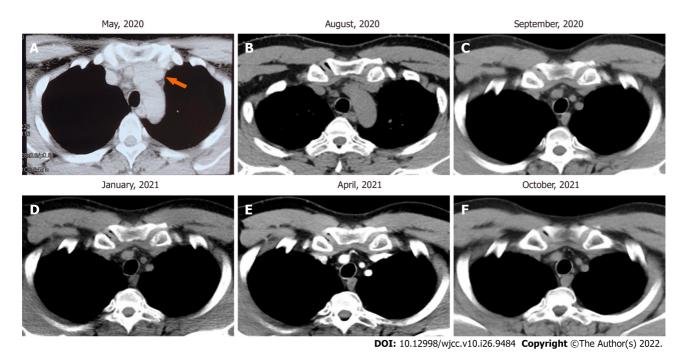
Preoperative chest computed tomography scan (tumor site was indicated by orange arrow) and postoperative computed tomography scan over time. A: Computed tomography (CT) scan image shows thymus mass before surgery; B-F: CT scan images show anterior mediastina region after surgery.
